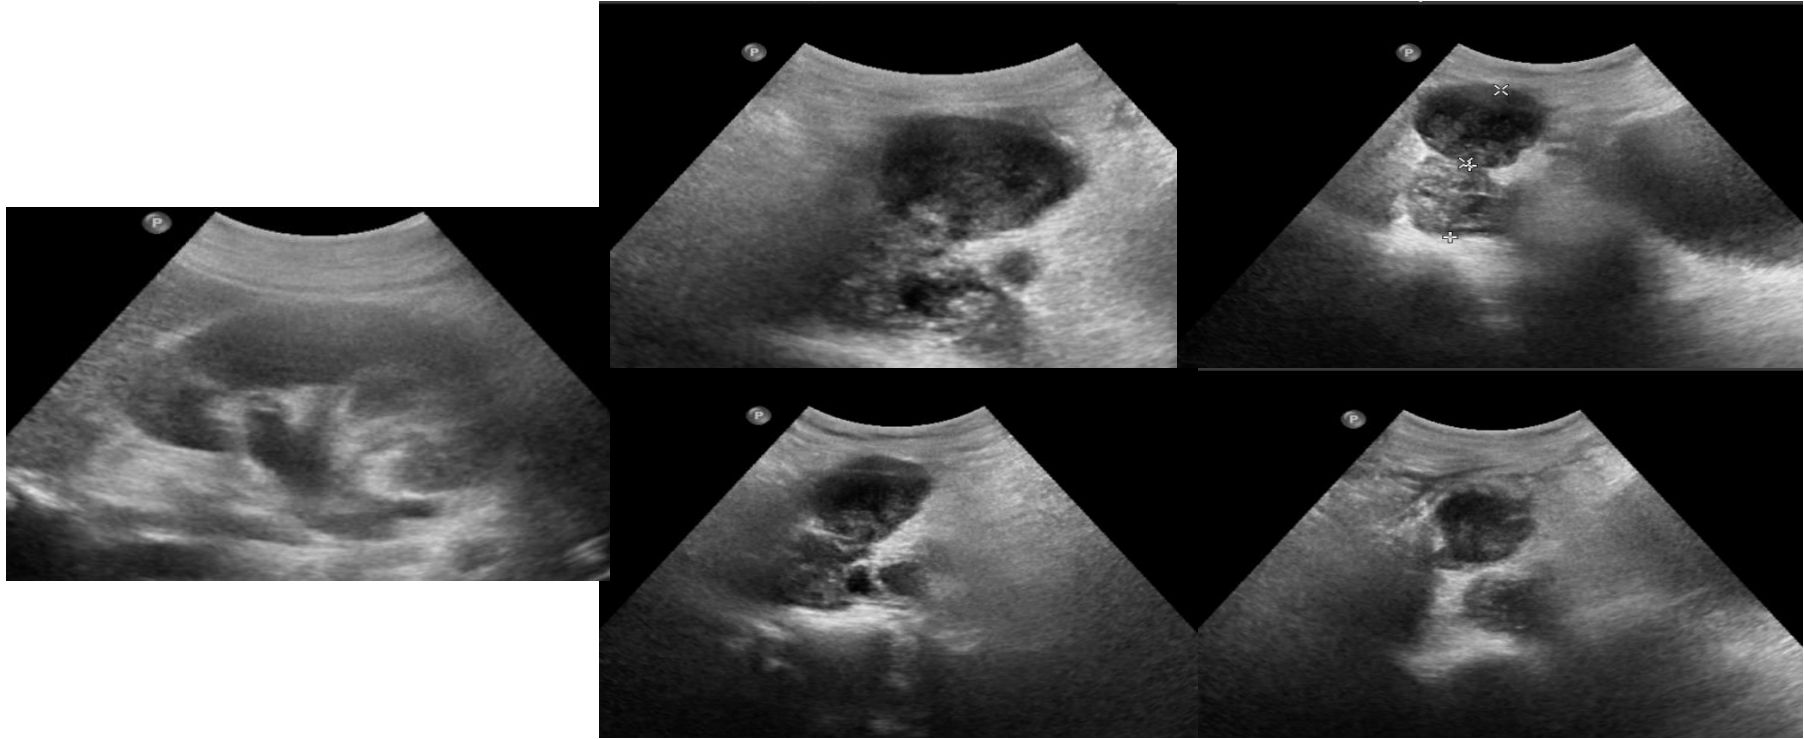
45 year old woman describes a 3 month history of dyspnea and oppressive sensation which she associated with stress. On physical examination, a mass was palpable in the right flank. Abdominal US demonstrates a heterogeneous mass in the right flank, with increased Doppler signal in the IVC location and lack of visibility of the vascular structure.
